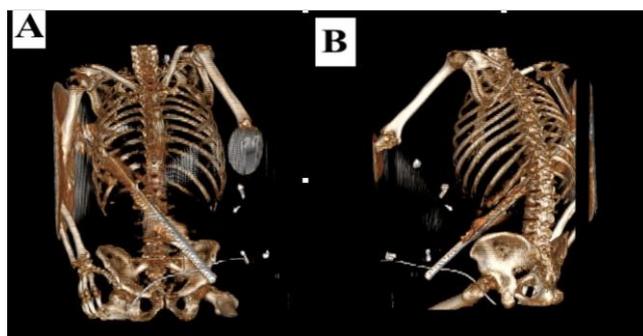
Three-dimensional CT image (A and B)
